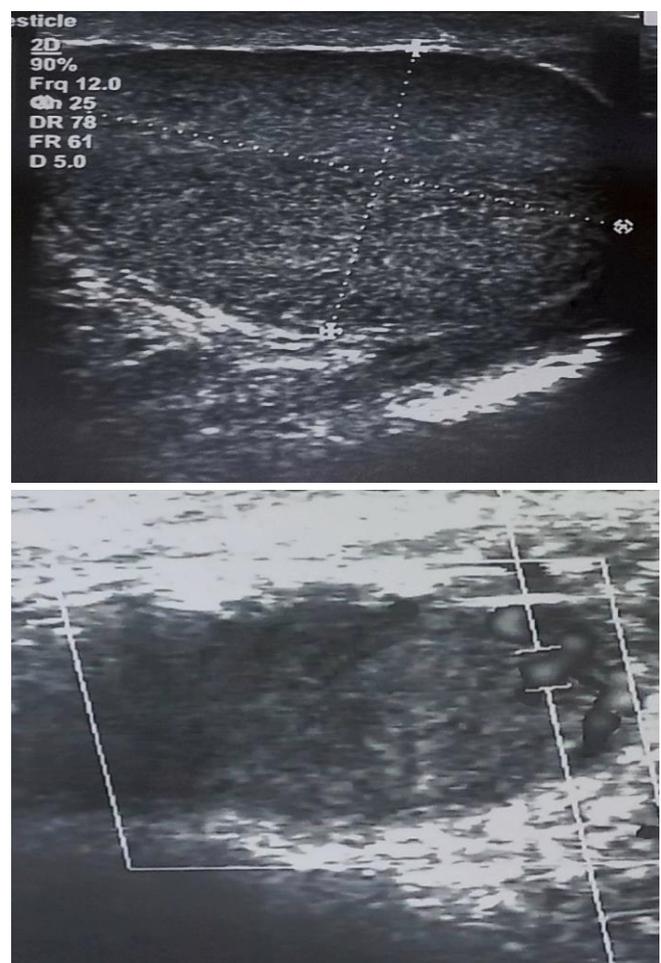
US scan and Doppler showing good echotexture and vascularity.
